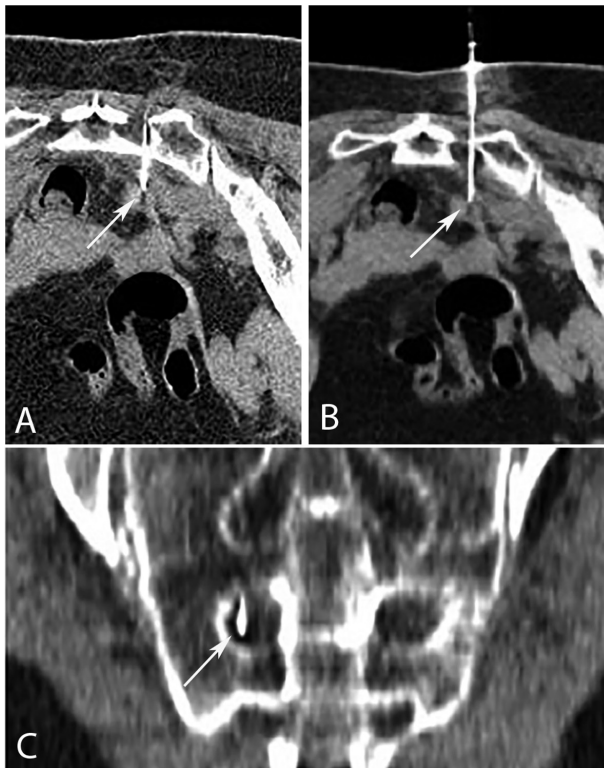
64-year-old female with an outcome of anterior resection of the rectum (12 months) for rectal adenocarcinoma. CT-guided FNA performed with the patient in the prone position sampled a right presacral lymph node (arrows in B). In this case, the coaxial technique was associated with the use of MPR images (C, coronal plane) in order to introduce the needle inside a sacral right foramen and to avoid anatomical obstacles such as bowel in front and sacrum posteriorly. Cytology showed the presence of intestinal carcinoma cells inside the sampled lymph node.
